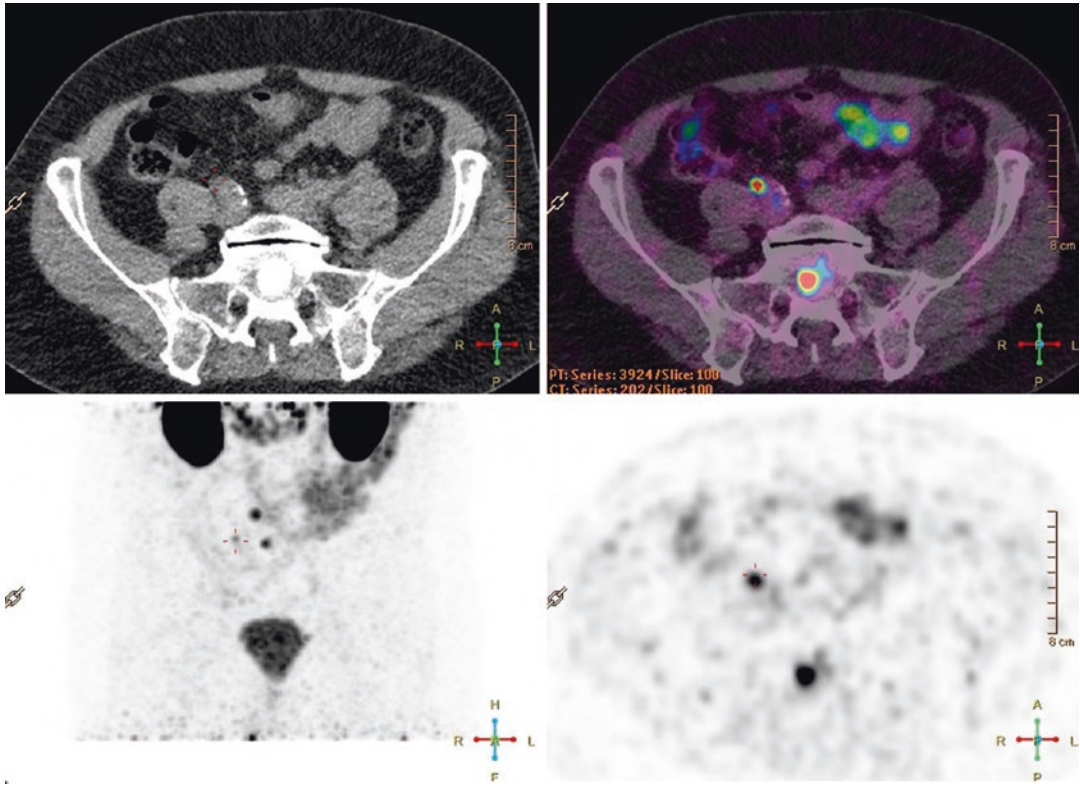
In these images multifocal pelvic lymph node metastases and a sacral bone metastasis are presented by ^{68}Ga -PSMA
